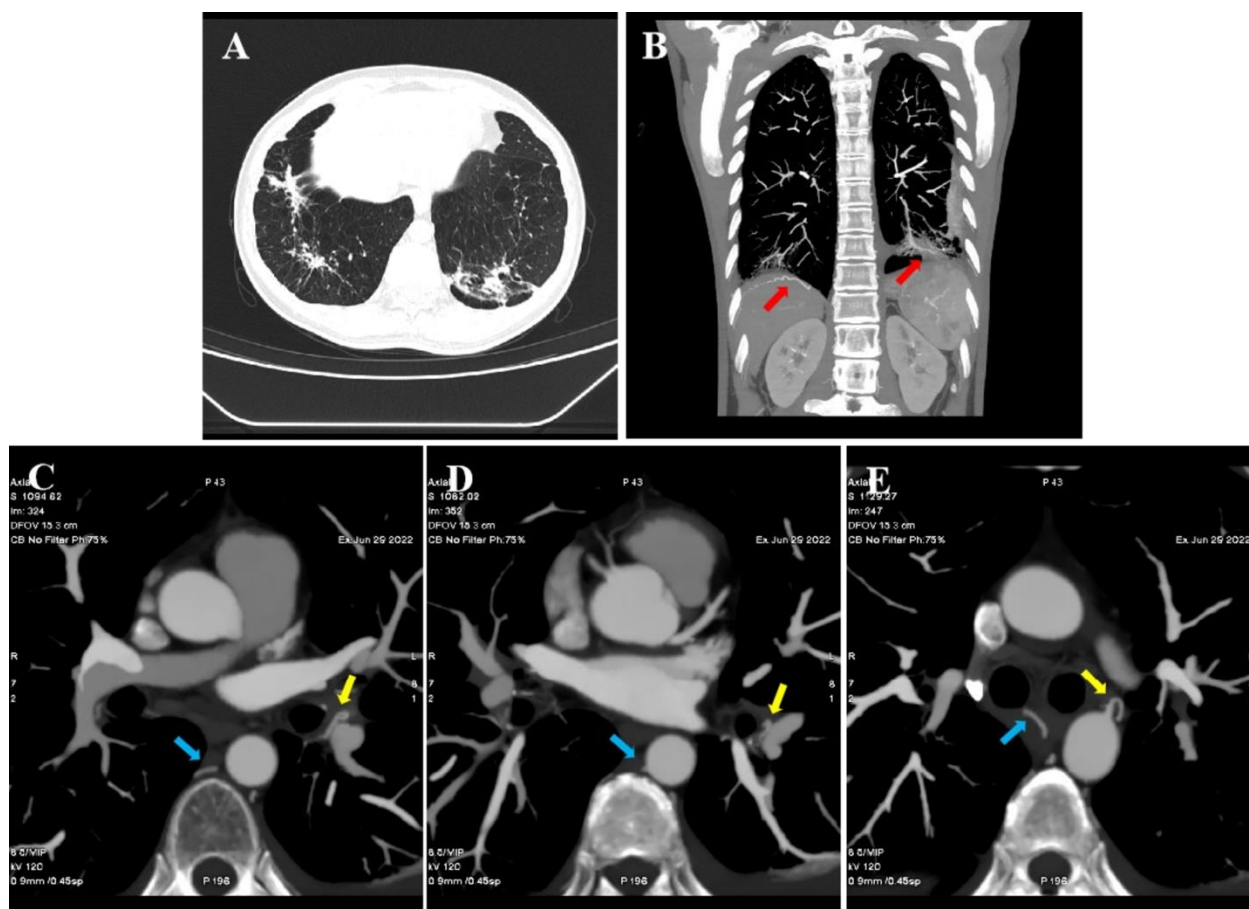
CT: Dilated and tortuous bilateral bronchial arteries. (A) Non-contrast chest CT revealed multiple areas of increased attenuation opacities in the bilateral lower lobes. (B) CT angiography: Dilation of pulmonary arteries and veins within the left lower lobe lesion. Tortuous dilation of the inferior phrenic artery (red arrow). (C-E) CT angiography: Dilated and tortuous bilateral bronchial arteries: Right bronchial artery (blue arrow); Left bronchial artery (yellow arrow).
